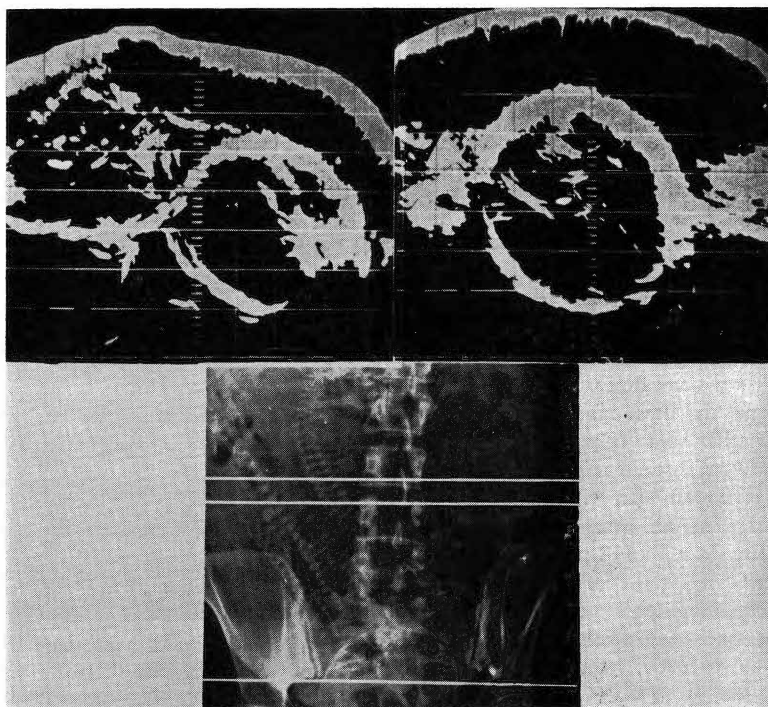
Sonogram of a multiple pregnancy showing, in the upper left, the outline of the fetal thorax in each of the twins. The head of the lower twin is outlined on the right. The corresponding X-ray showing the cross-sectional levels of the sonograms is shown below. Reprinted from *Am. J. Obstet. Gynec.* 90: 655, 1964 (C. V. Mosby).
